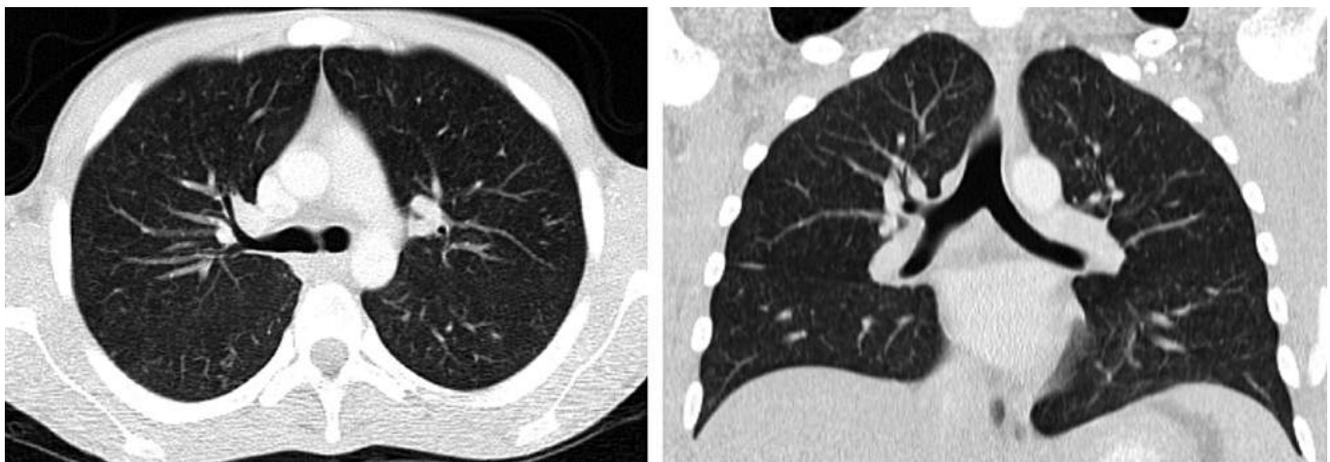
Coronal and cross-sectional high-resolution chest CT. Bilateral randomly distributed micronodules, some forming a budding tree pattern. Source: Patient's medical record.
